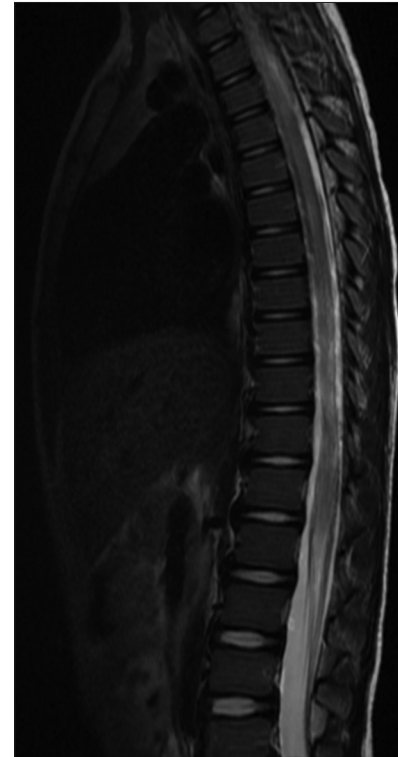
Sagittal view of magnetic resonance imaging dorsal spine showing T2 hyperintensities extending from D1-D12 vertebrae with cord edema
